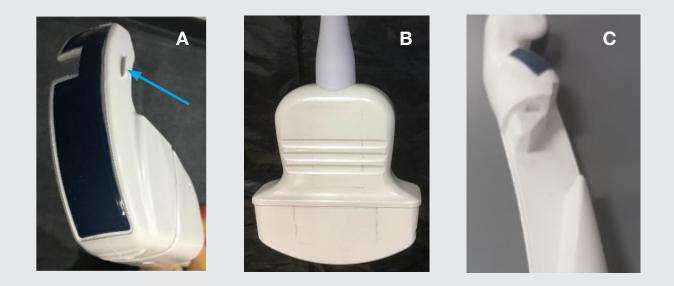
Examples of surface features of ultrasound probes: an orientation marker located on the side of the probe body (A); grooves to assist with grip (B); notch for attachment of needle guide (C).
